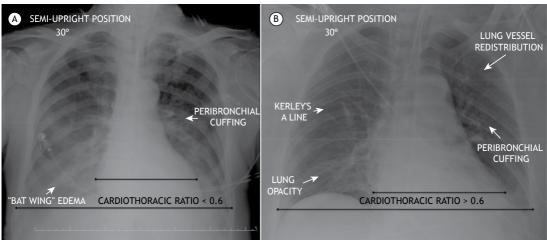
In A, a chest X-ray of a 68-year-old female patient shows peribronchial cuffing and opacity in a "bat wing" pattern, revealing edema, compounding a radiological score of 4 points, characterized as interstitial lung congestion. (16) In B, a chest X-ray of a 57-year-old male patient shows a cardiothoracic ratio > 60%, peribronchial cuffing, lung vessel redistribution, Kerley's A line, and lung opacity, resulting in a score of 5 points, characterized as mild alveolar edema. (16)
